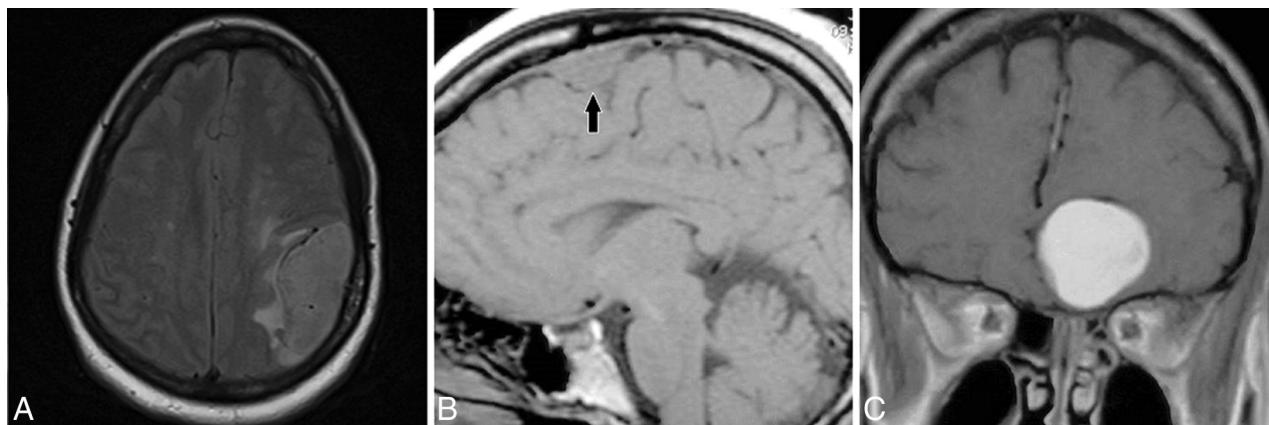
Three different cases of chordoid meningioma show the characteristic T1, T2 FLAIR, and postcontrast T1 appearances, which are similar to those of other meningioma subtypes. *A*, T2-weighted FLAIR image shows slight hyperintensity to gray matter with mild surrounding edema. *B*, T1-weighted image shows isointensity of the chordoid meningioma (arrow) to gray matter. *C*, Contrast-enhanced T1-weighted image shows avid homogeneous enhancement of the meningioma.
